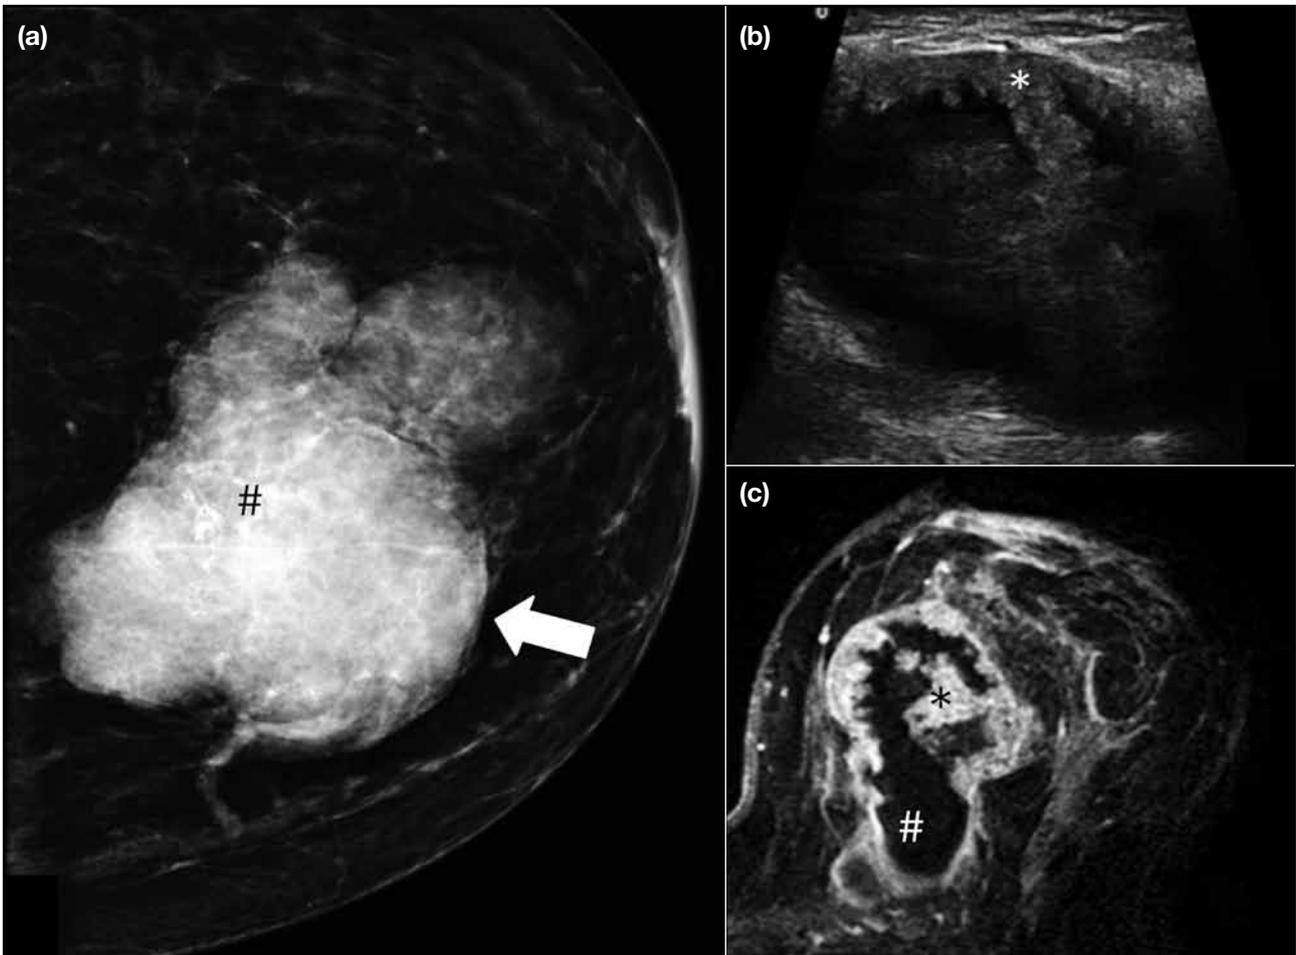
(a) Craniocaudal mammogram of the left breast of a 54-year-old woman showing a hyperdense irregular mass (#) with circumscribed margins (arrow) and pleomorphic calcifications, occupying the medial quadrants of the breast. (b) Ultrasound image showing an oval complex mass with circumscribed margins and a peripheral solid component (*) with centripetal projections. (c) T1-weighted contrast-enhanced magnetic resonance image showing an irregular mass (#) with a necrotic centre and solid (*) components.
